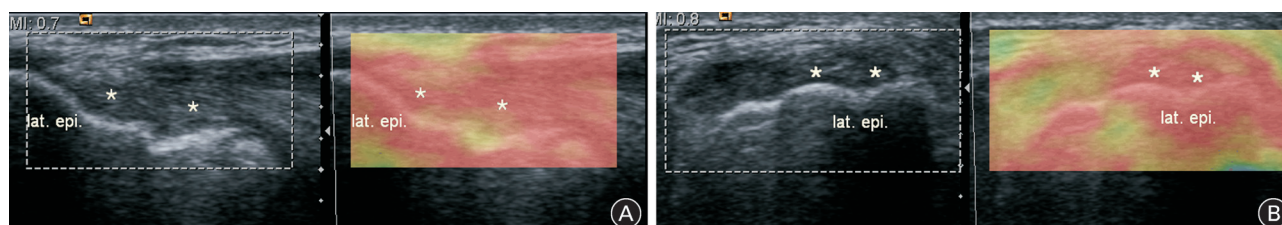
An asymptomatic elbow with a normal common extensor tendon in a 45-year-old patient (A: longitudinal view; B: transverse view). The greyscale ultrasonographic images (left) show the normal structure of the common extensor tendon (asterisks) and the sonoelastographic images (right) show sonoelastographic score 4 (hard) with the red elastic spectrum. lat. epi.=lateral epicondyle.
